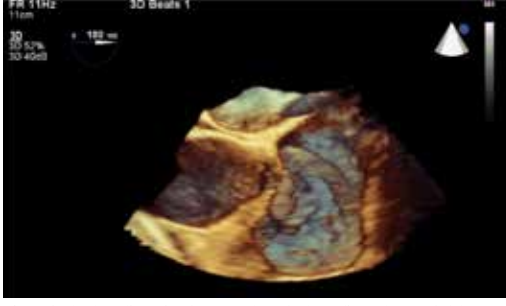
The three dimensional transesophageal echocardiography revealed the actual tube like nature of the mass.
